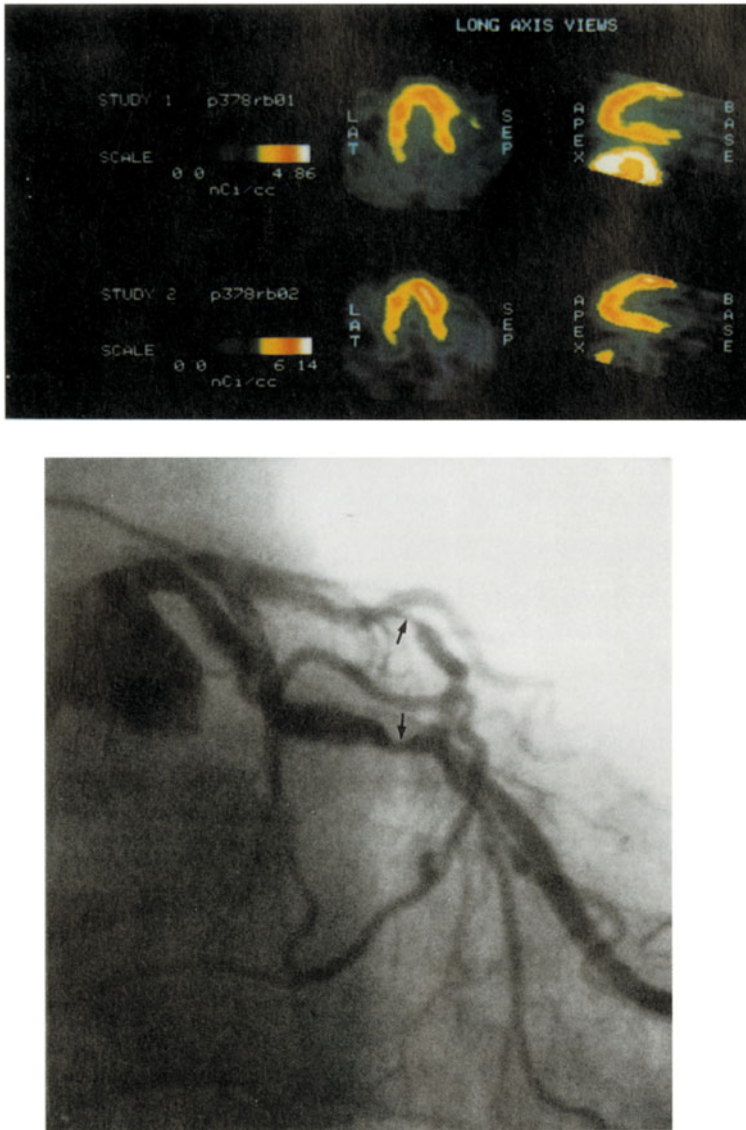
False negative PET perfusion scintigraphy with LV hypertrophy. Perfusion is homogeneous at rest (“rb01”) and stress (“rb02”) despite two-vessel coronary disease (bottom).
